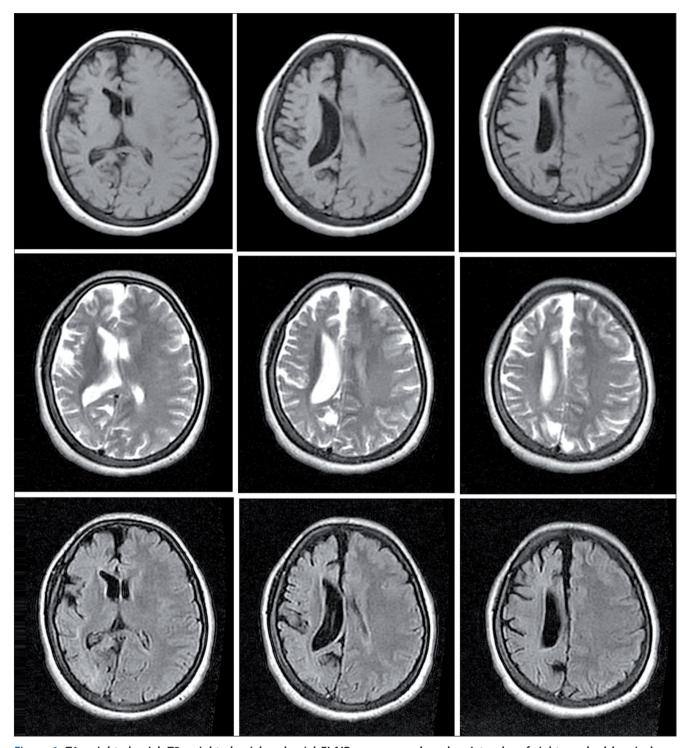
T1-weighted axial, T2-weighted axial and axial FLAIR sequences show hemiatrophy of right cerebral hemisphere, dilatation of the right lateral ventricle, widening of ipsilateral cortical sulci, and unilateral thickening of calvarium.
